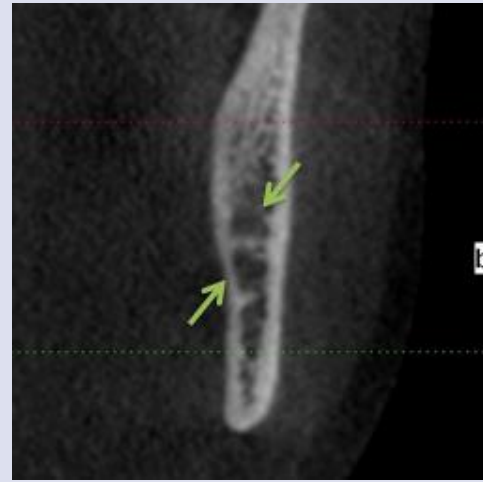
BMC on the left side of the mandible in the axial tomographic (cone-beam computerized tomography) section.
